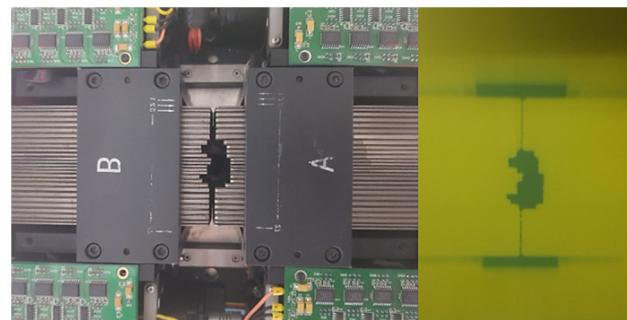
Image of X-ray irradiation controlled by MLC operation in the O-arm CT-LINAC system.
